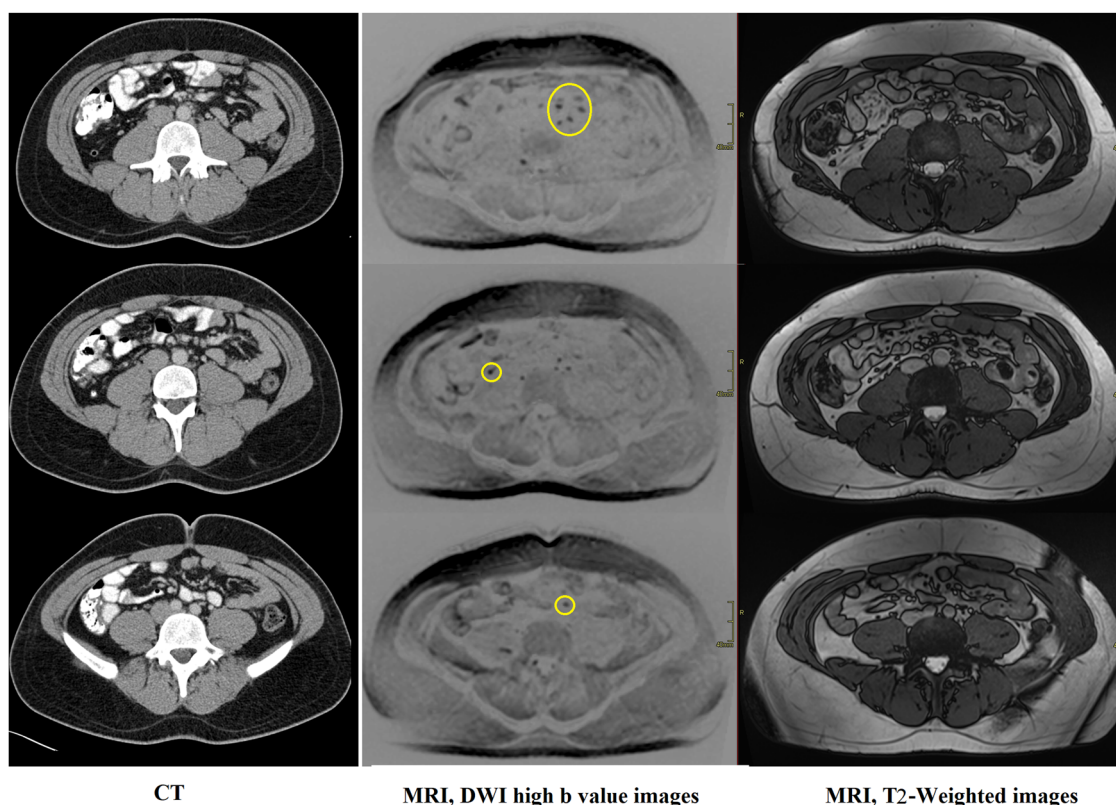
A 25-year-old man treated for a stage 1 NSGCT. On follow-up MRI, several sub-centimeter mesenteric LNs were observed, showing restricted diffusion (yellow circles). On CT, these mesenteric LNs were unremarkable. Patient was followed up, and the LNs remained stable, indicating benign nature. The MRI findings were considered false-positive in this case
